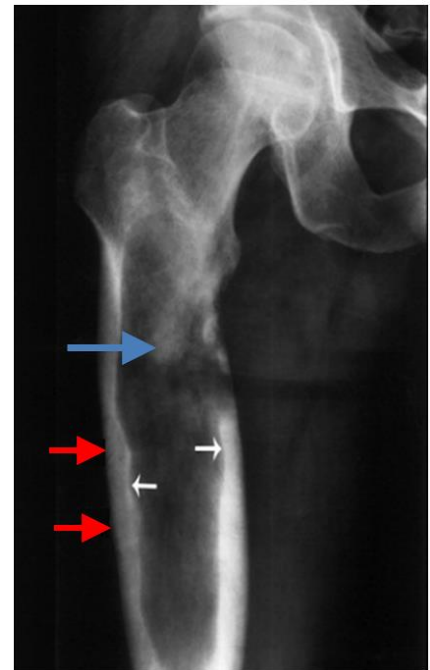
A) Percent distribution of chondrosarcoma patients per age. Adapted from (Damron, Ward et al. 2007). B) Frequency distribution of chondrosarcoma tumors across the skeleton. Figure adapted from (van Oosterwijk, Anninga et al. 2013). C) X-ray radiography showing a chondrosarcoma tumor presenting lytic lesion in the right femur with cortical endosteal scalloping (erosion of the inner cortex, white arrows), chondroid matrix production (blue arrow) and cortical thickening (red arrows). Adapted from (Littrell, Wenger et al. 2004)
